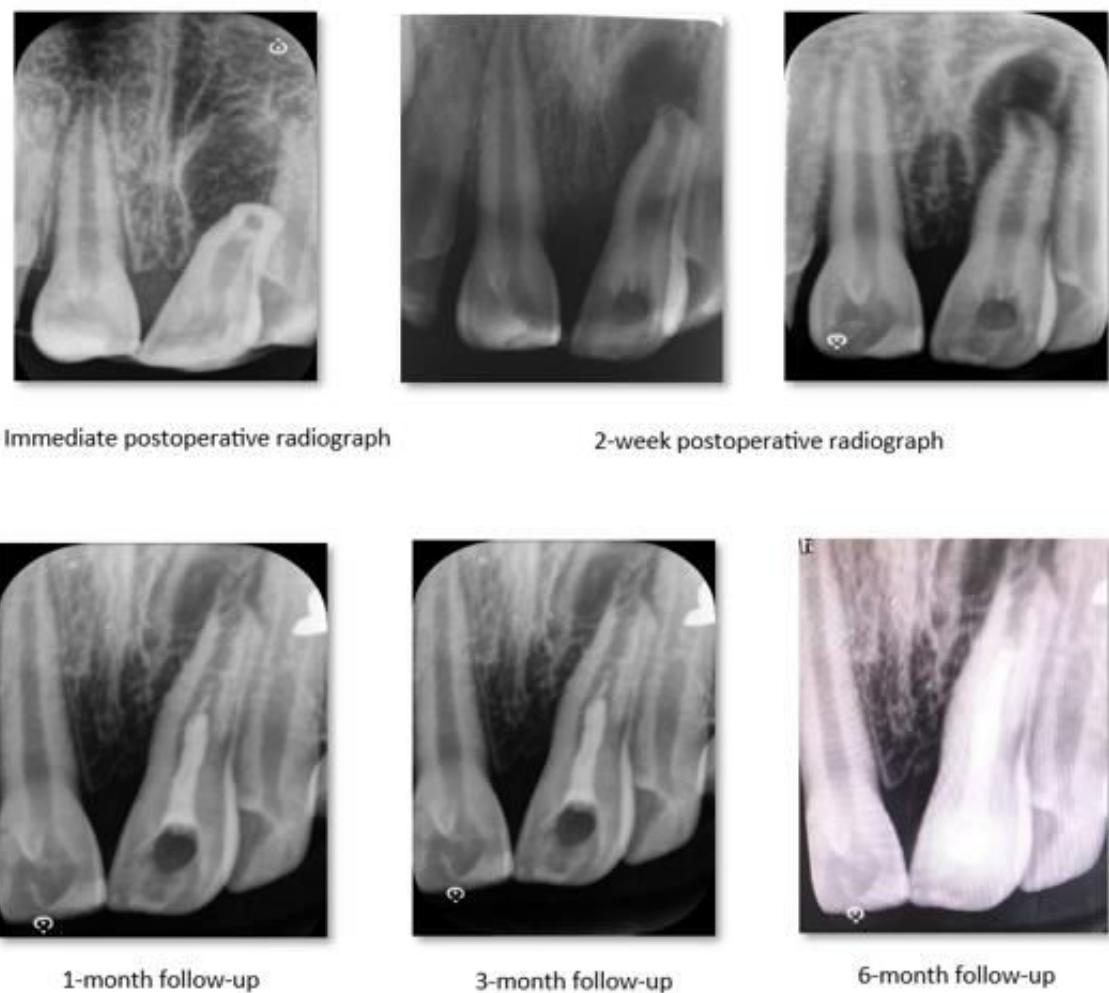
Radiographic evaluation 1,3 and 6 months.
